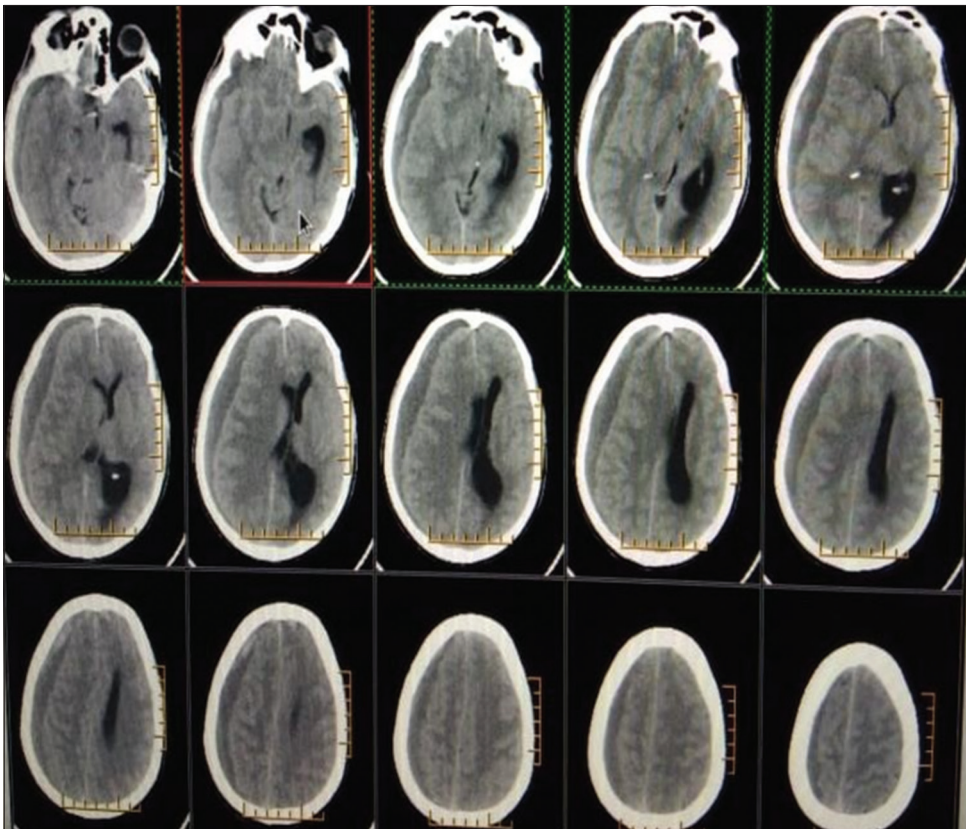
Non-contrast computed tomography on day of presentation with right fronto-temporo-parietal chronic subdural hematoma with mass effect
